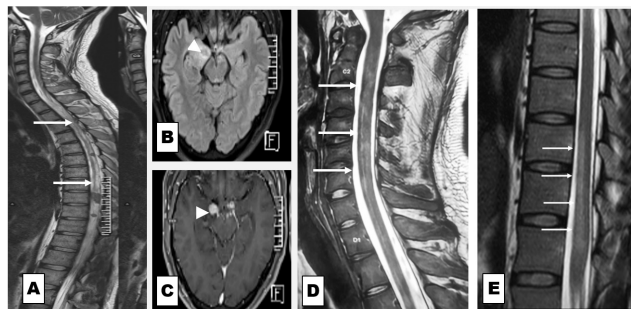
(A to E): (A): MRI Spine sagittal T2W image showing longitudinally extensive T2 hyperintensity from C7 to D8 with cord edema (white arrows) and multiple small nodular lesions, suggestive of granulomatous etiology (seen in case 1); (B and C): MRI Brain axial FLAIR image and T1W post contrast image showing FLAIR-hypointense lesion with surrounding edema in the right medial temporal lobe with post-contrast nodular enhancement (arrow heads) suggestive of CNS tuberculosis with both spinal and intracranial involvement (seen in case 1); (D): MRI spine sagittal T2 weighted image showing the characteristic “glass-eel” appearance- slender, translucent, uninterrupted T2 signal involving the central cord in Chikungunya myelitis (white arrows) (seen in case 2); (E): MRI spine sagittal T2 weighted image showing long-segment T2 hyperintense lesion extending from the mid-thoracic cord to the conus, without enhancement or significant cord expansion in post-COVID myelitis (white arrows) (seen in case 3)
